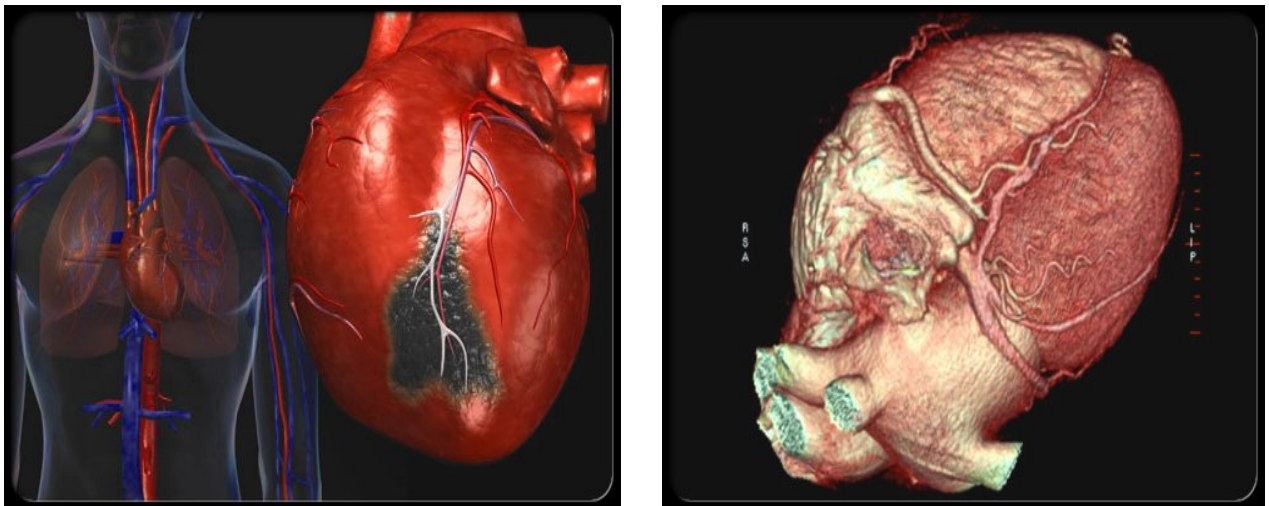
Block shows in Infarcted area and 18 sliced CT angiogram
